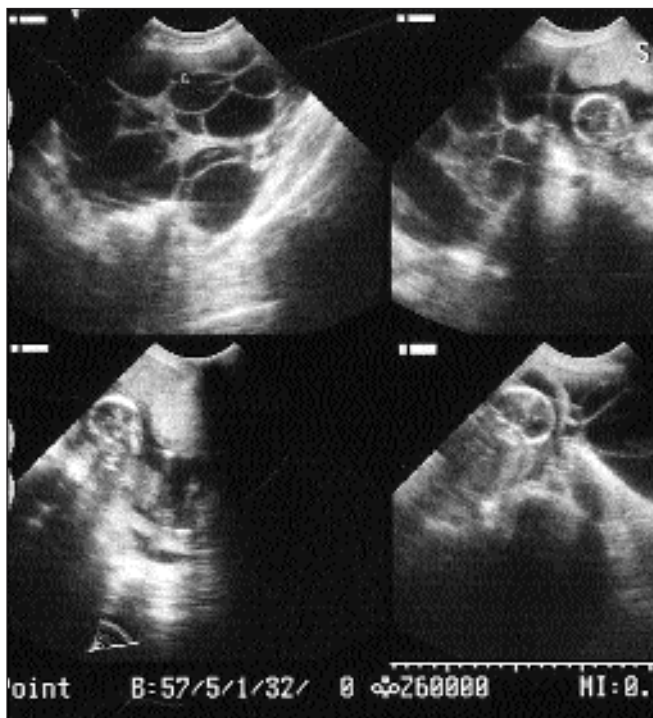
Ultrasonographic appearance of the pregnant uterus and bilaterally enlarged ovaries.
